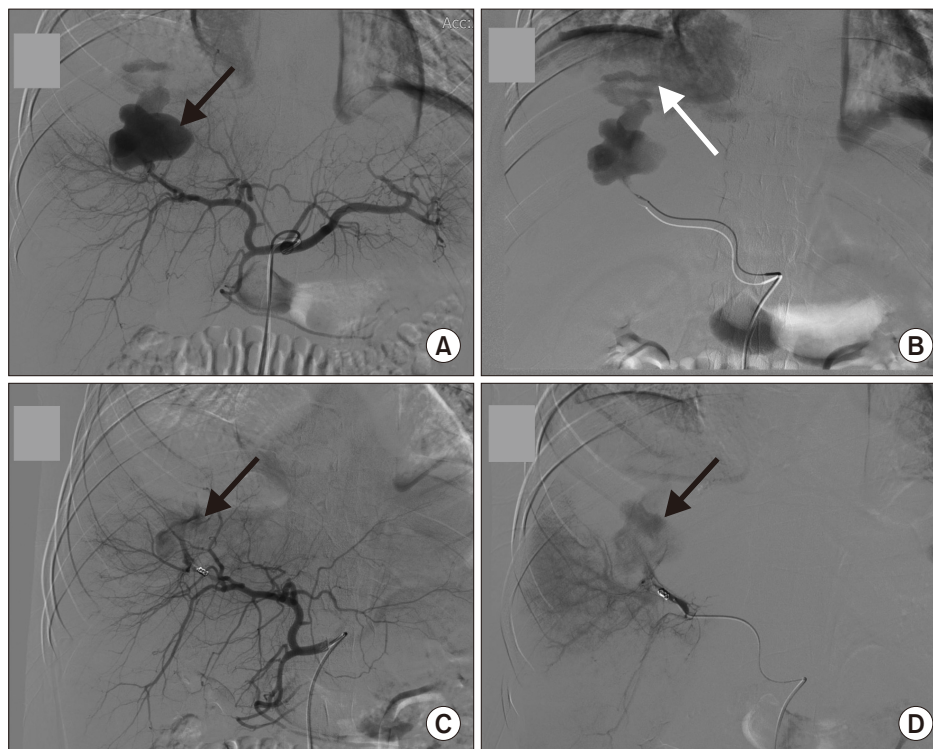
Angiographic images from celiac trunk (A) and selective anterior segmental hepatic artery (B) show the pseudoaneurysm (black arrow in A) and arteriohepatic venous fistula draining into the right hepatic vein (white arrow), confirming the multislice computed tomography diagnosis. A 3 mm \times 60 mm fibred coil was deployed at the neck of the pseudoaneurysm. On post-coiling embolization angiogram (C, D), the pseudoaneurysm was still perfused via collaterals (black arrows).
